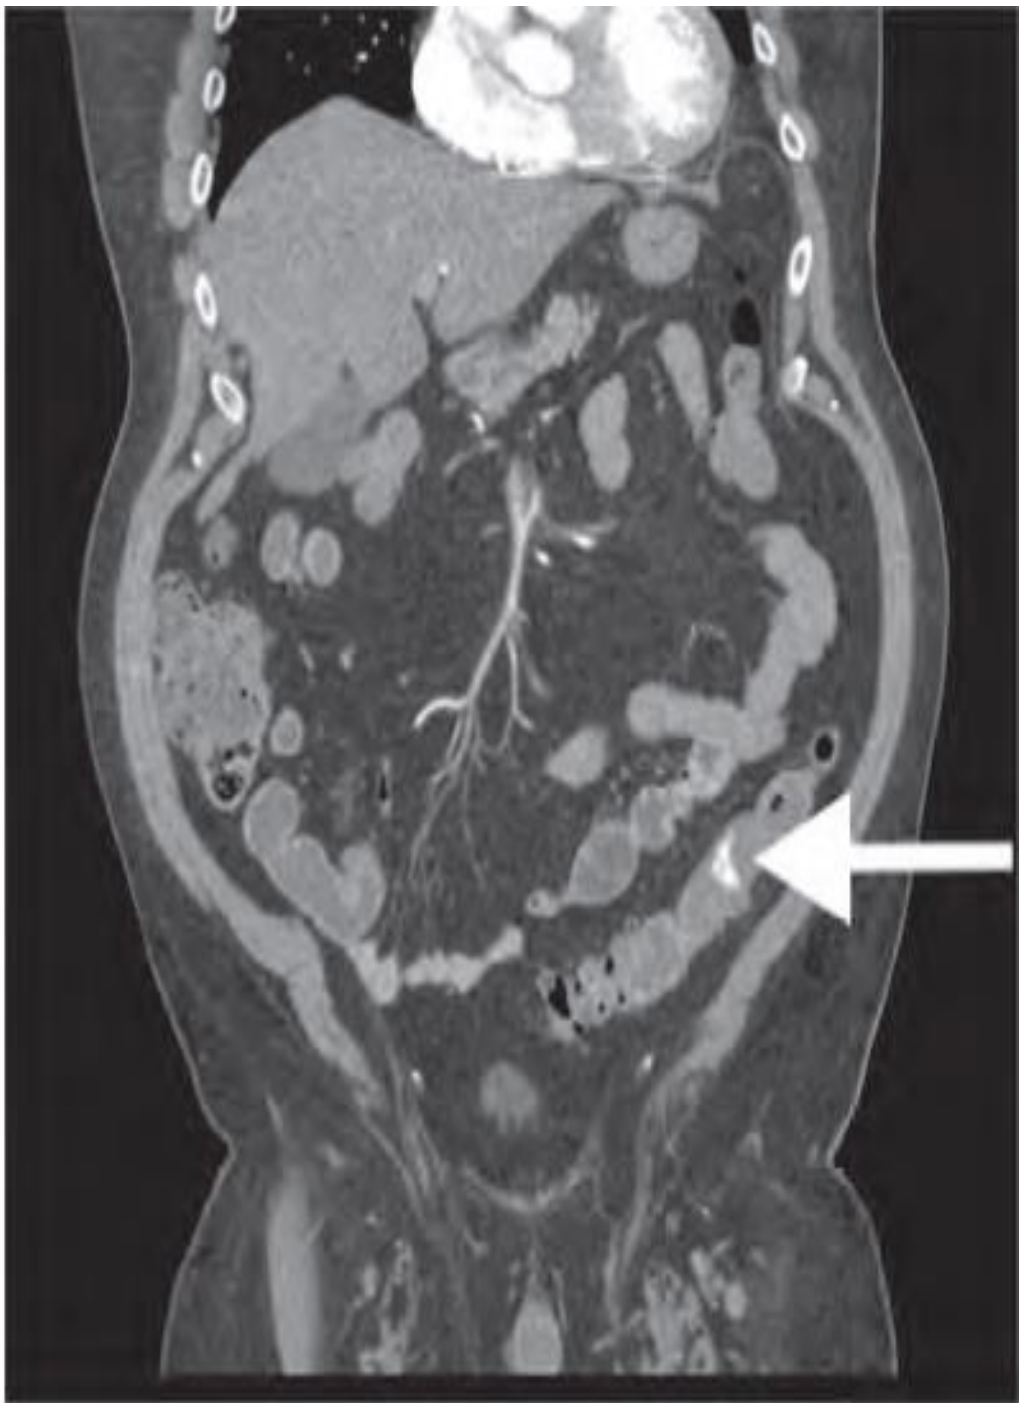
Axial and coronal images from CT angiograms demonstrating extravasation of contrast material within the colon from a bleeding diverticulum. (Courtesy Wendy B. Landman, MD; Department of Radiology Brigham and Women's Hospital.)
